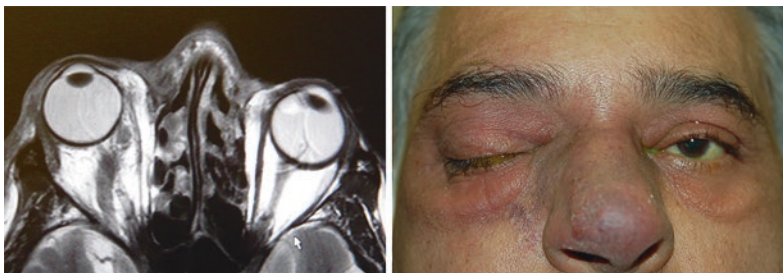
Newly diagnosed type 2 diabetes patient presenting with orbital cellulitis complicated by cavernous sinus thrombosis. Enlarged superior ophthalmic vein and proptosis shown on T2-weighted axial MRI (left)
